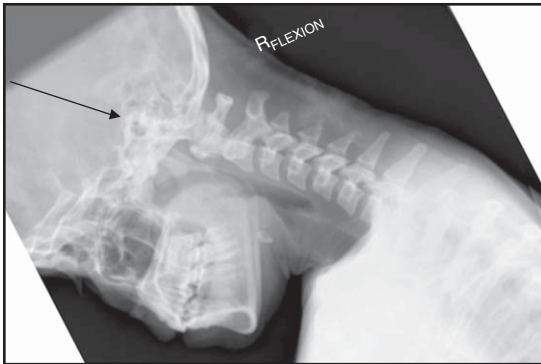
A flexion lateral cervical radiograph demonstrating the mechanism of cervical injury that occurs with spear tackling. When the neck is flexed, as is the case when a player spear tackles, contact is initiated with the crown of the helmet. With the neck in a flexed position, the alignment of the cervical spine is straight to slightly kyphotic, as demonstrated in the lateral cervical radiograph. Almost the entire applied load (black arrow) is axially applied to the cervical spinal column. When this load is excessive, the cervical spinal column fails in a flexion and compression (see figure 3).
